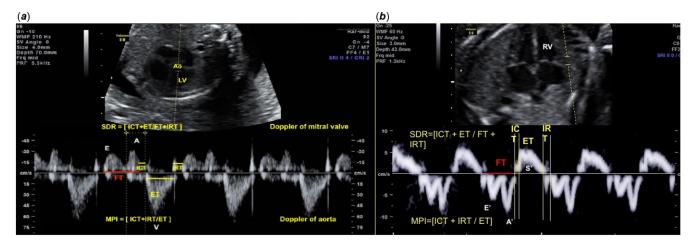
Fetal echocardiography showing the cardiac cycle intervals and the formulas to calculate: 1-MPI and 2-SDR. (*A*) MPI and SDR of the left ventricle using spectral Doppler. (*B*) MPI and SDR of the right ventricle using tissue Doppler. Formulas: MPI = ICT + IRT/ET and SDR = ICT + ET/FT + IRT. SDR = systolic-to-diastolic duration ratio by spectral Doppler; SDR' = systolic-to-diastolic duration ratio by tissue Doppler; MPI = myocardial performance index; ET = ejection time; FT = filling time; ICT = isovolumetric contraction time; IRT = isovolumetric relaxation time; E = E wave of mitral valve flow; A = A wave of mitral valve flow; E' = E wave of tricuspid valve flow by tissue Doppler; A' = A wave of tricuspid valve flow; S' = pulmonary artery flow by tissue Doppler (systolic wave).
